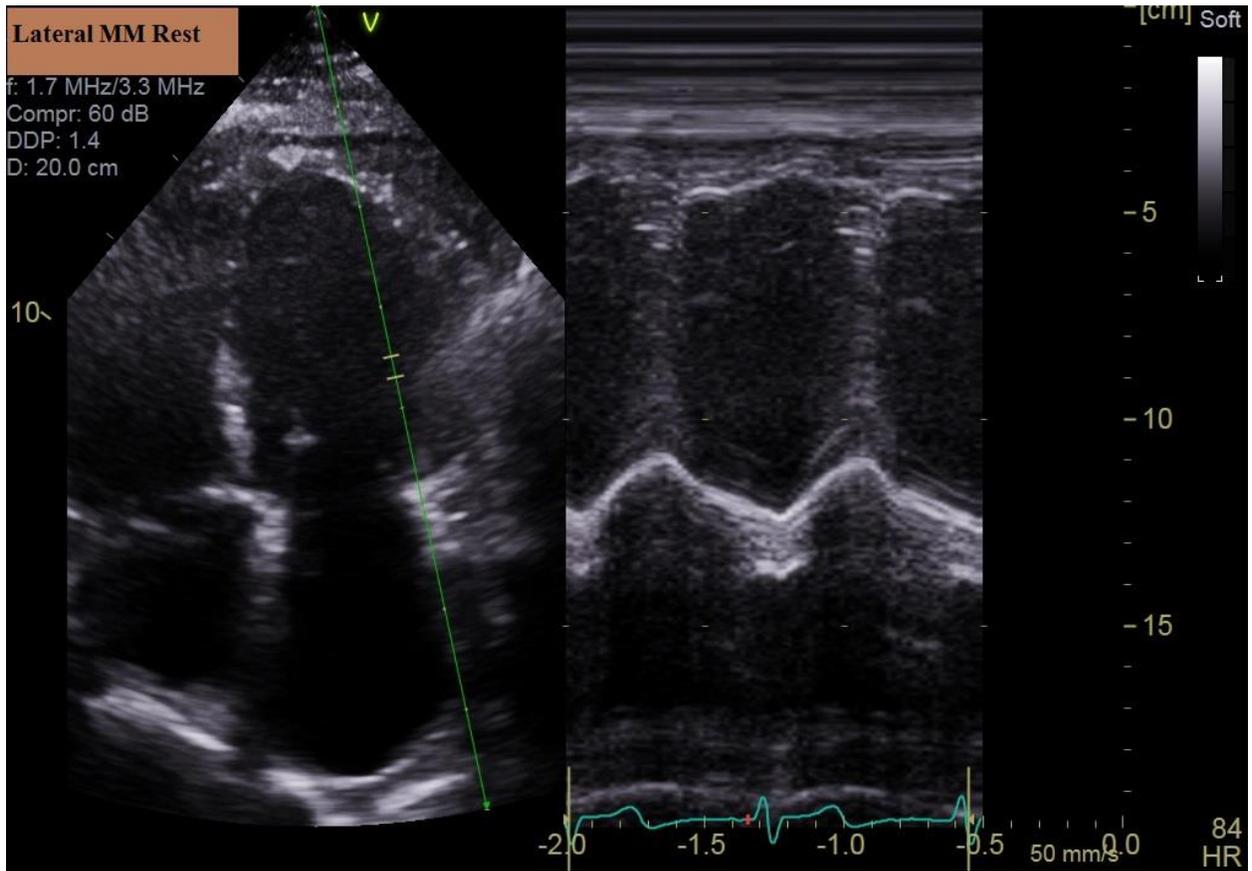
Trans-thoracic echocardiography, Lateral M-mode at rest.
